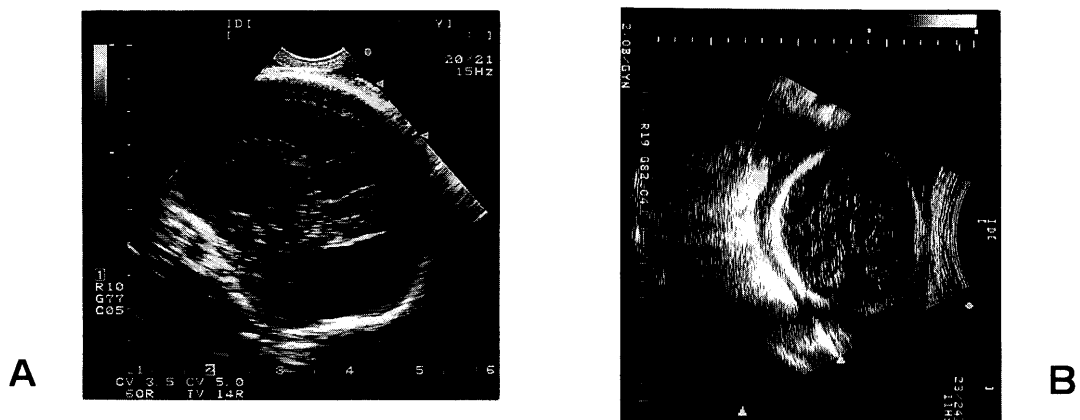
Prenatal ultrasonography findings at 31 weeks of gestation. A, Sagittal scan. A large free space in the posterior fossa cyst, dysgenesis of the cerebellar vermis and elevation of the tentorium were noted. B, Axial scan. A cystic dilatation of the fourth ventricle with splaying in the cerebellar hemispheres was noted.
